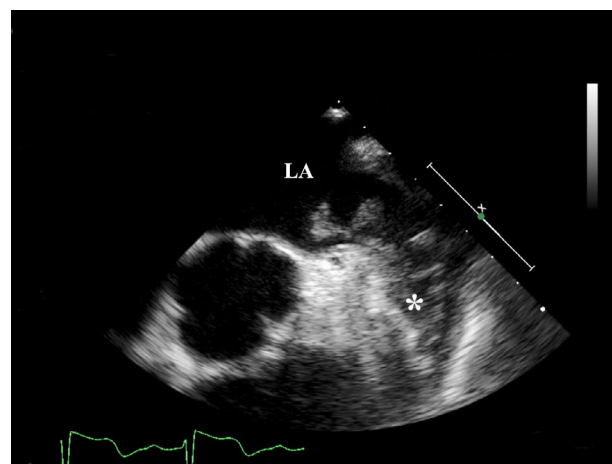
Transesophageal echocardiogram reveals a large echogenic density (asterisk) in LAA suggestive of thrombus with mobile elements.
